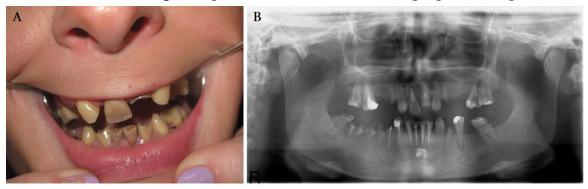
Patient K.S., A.O.'s mother (A). Patient K.S. Orthopantomography (B) dentin and cementum caries; number of carious teeth - 3, number of tooth filling - 11, number
